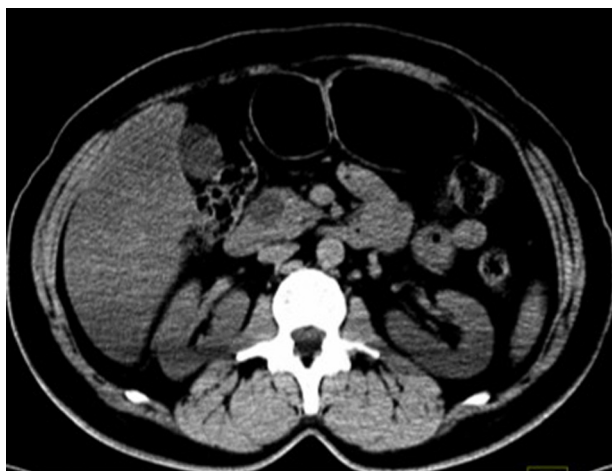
CT scan with hypodense cystic lesion located in the head and uncinate process of the pancreas that measures 20×11 mm.
